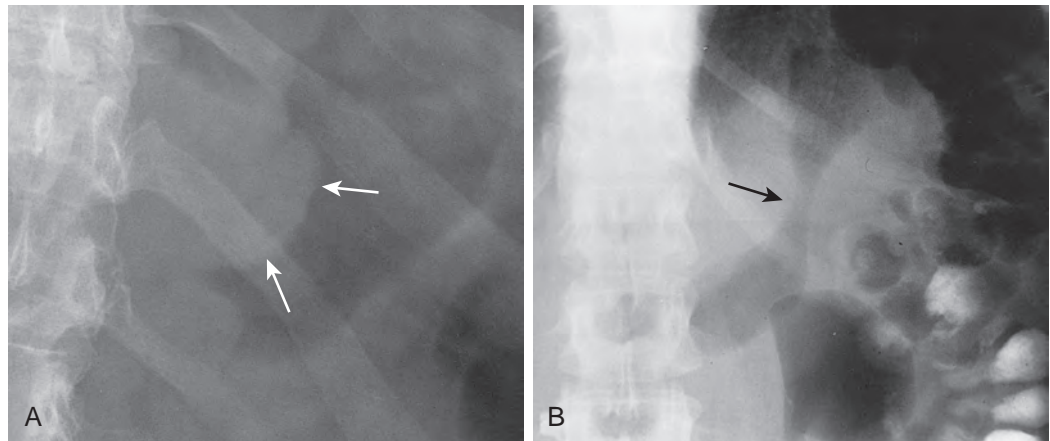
Findings of gastric carcinoma on abdominal radiographs. A. Close-up view from an abdominal radiograph shows a soft tissue mass (arrows) indenting the lesser curvature of the gas-filled stomach. This was a polypoid gastric carcinoma. B. In another patient, the gas-filled stomach has a narrowed, tubular appearance (arrow) caused by a scirrhous carcinoma (linitis plastica).
